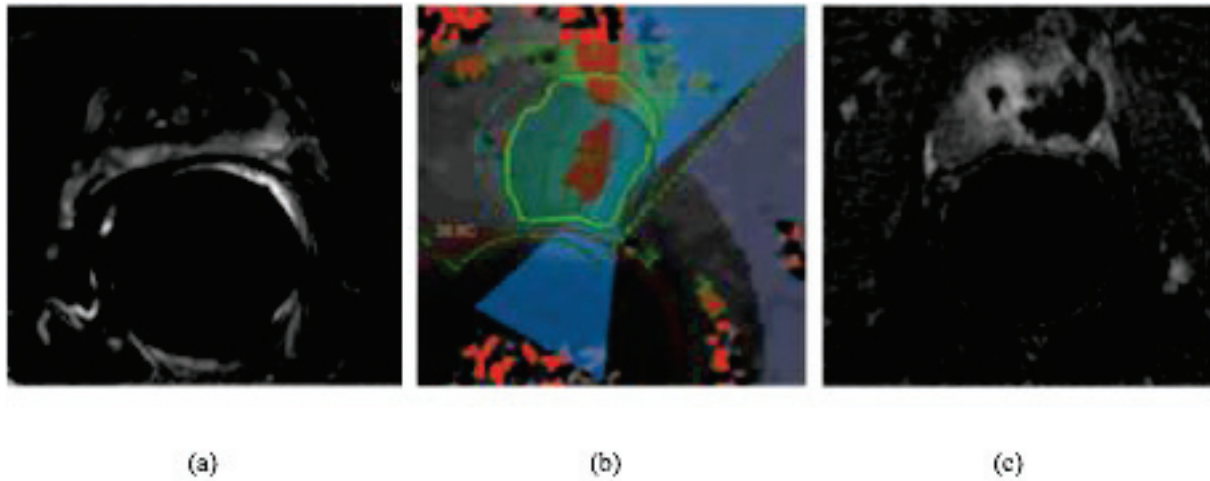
(a) Gleason 6 (3 + 3) tumor of the left prostatic lobe in a 63 years old patient is detected as a homogenous focus of low signal intensity on a transverse T2-weighted MR images; (b) real time monitoring allows continuous control of temperature variations while sonications are performed under MR guidance; (c) Axial T1-weighted Gradient Echo images after injection of gadolinium, performed after MRgFUS treatment shows tissue necrosis in the area of ablation.
